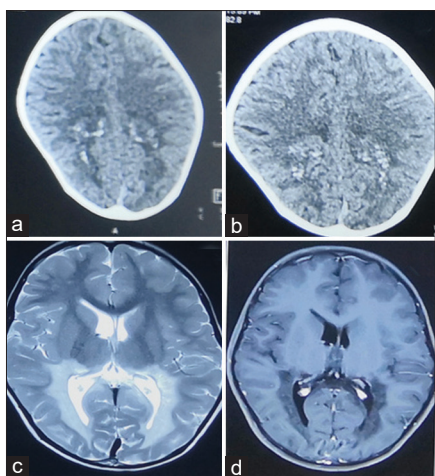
Neuroimaging of the index child. Contrast Computed tomography images show calcifications in bilateral parieto-occipital white matter (a, b); T2W MRI images show confluent hyperintense signal intensities in parieto-occipital periventricular white matter (c) and T1W contrast MRI images showing no contrast enhancement (d)
